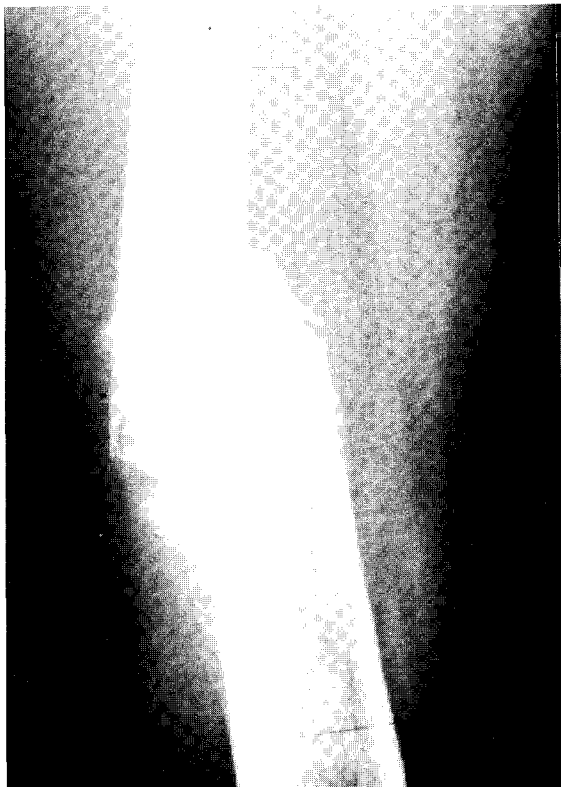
M.A. X-ray after infusion + perfusion, even in this case bone rearrangement and recalcification are evident.
